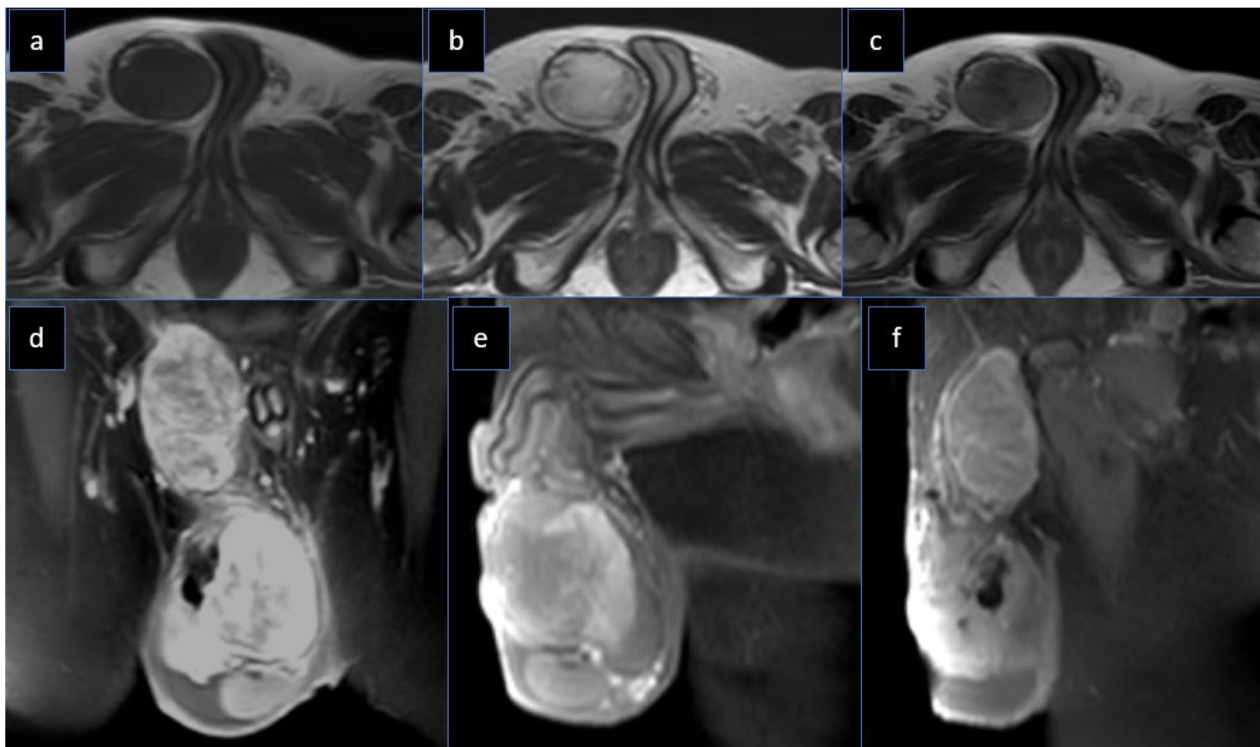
Pre and Post-contrast MRI: a, b and c axial images: a right spermatic cord lesion displaying low signal in T1 (a) and high SI in T2 (b) with heterogenous enhancement in T1 with contrast (c), d coronal FAT-SAT image: enhancing right inguinal and right paratesticular masses showing no signal drop with signal void calcification, e and f sequential sagittal FAT-SAT images: a paratesticular mass inseparable from the right testicle and an enhancing spermatic cord lesion, respectively
